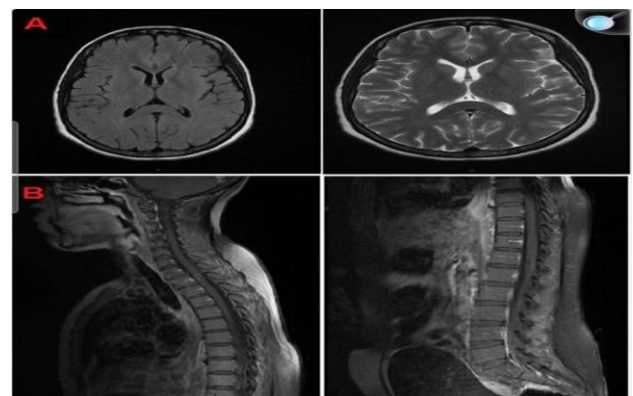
(A and B): Encephalitic and medullary MRI of our patient showing no abnormalities.
